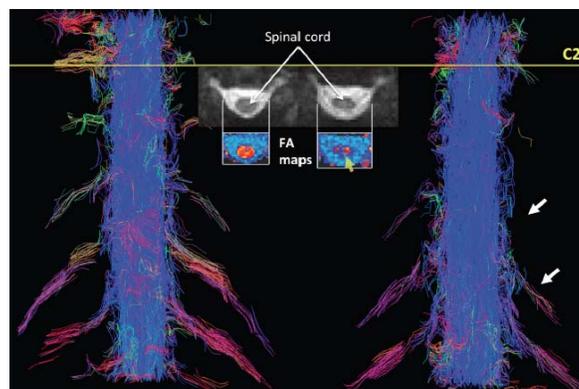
Diffusion MRI of the spinal cord showing alteration of the nerve roots (white arrows) in age-matched patient (right) and control (left). Cord atrophy was visualized and quantified using fractional anisotropy (FA) maps (center images depicting axial slices through C2), which correlate with white matter integrity. Lower values (blue colors in the center FA maps) can be seen in the spinal cord for the patient's data (yellow arrow).
